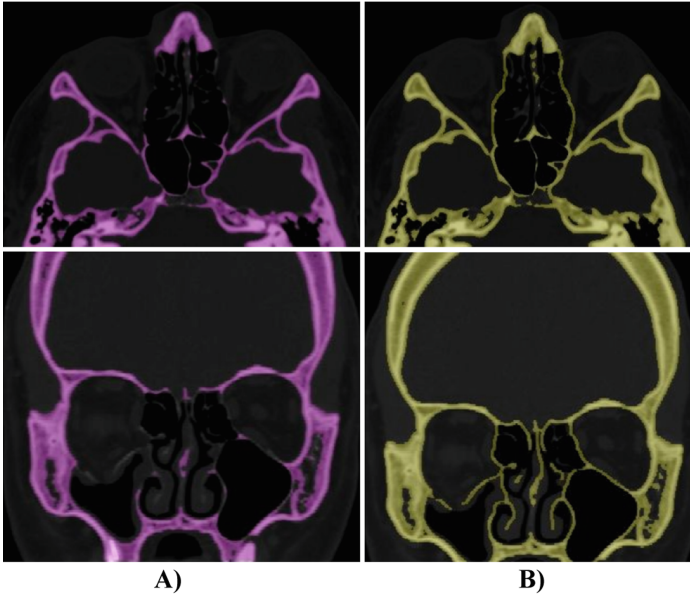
Axial and sagittal CT images, A) before orbital walls editing, B) after orbital walls editing.
